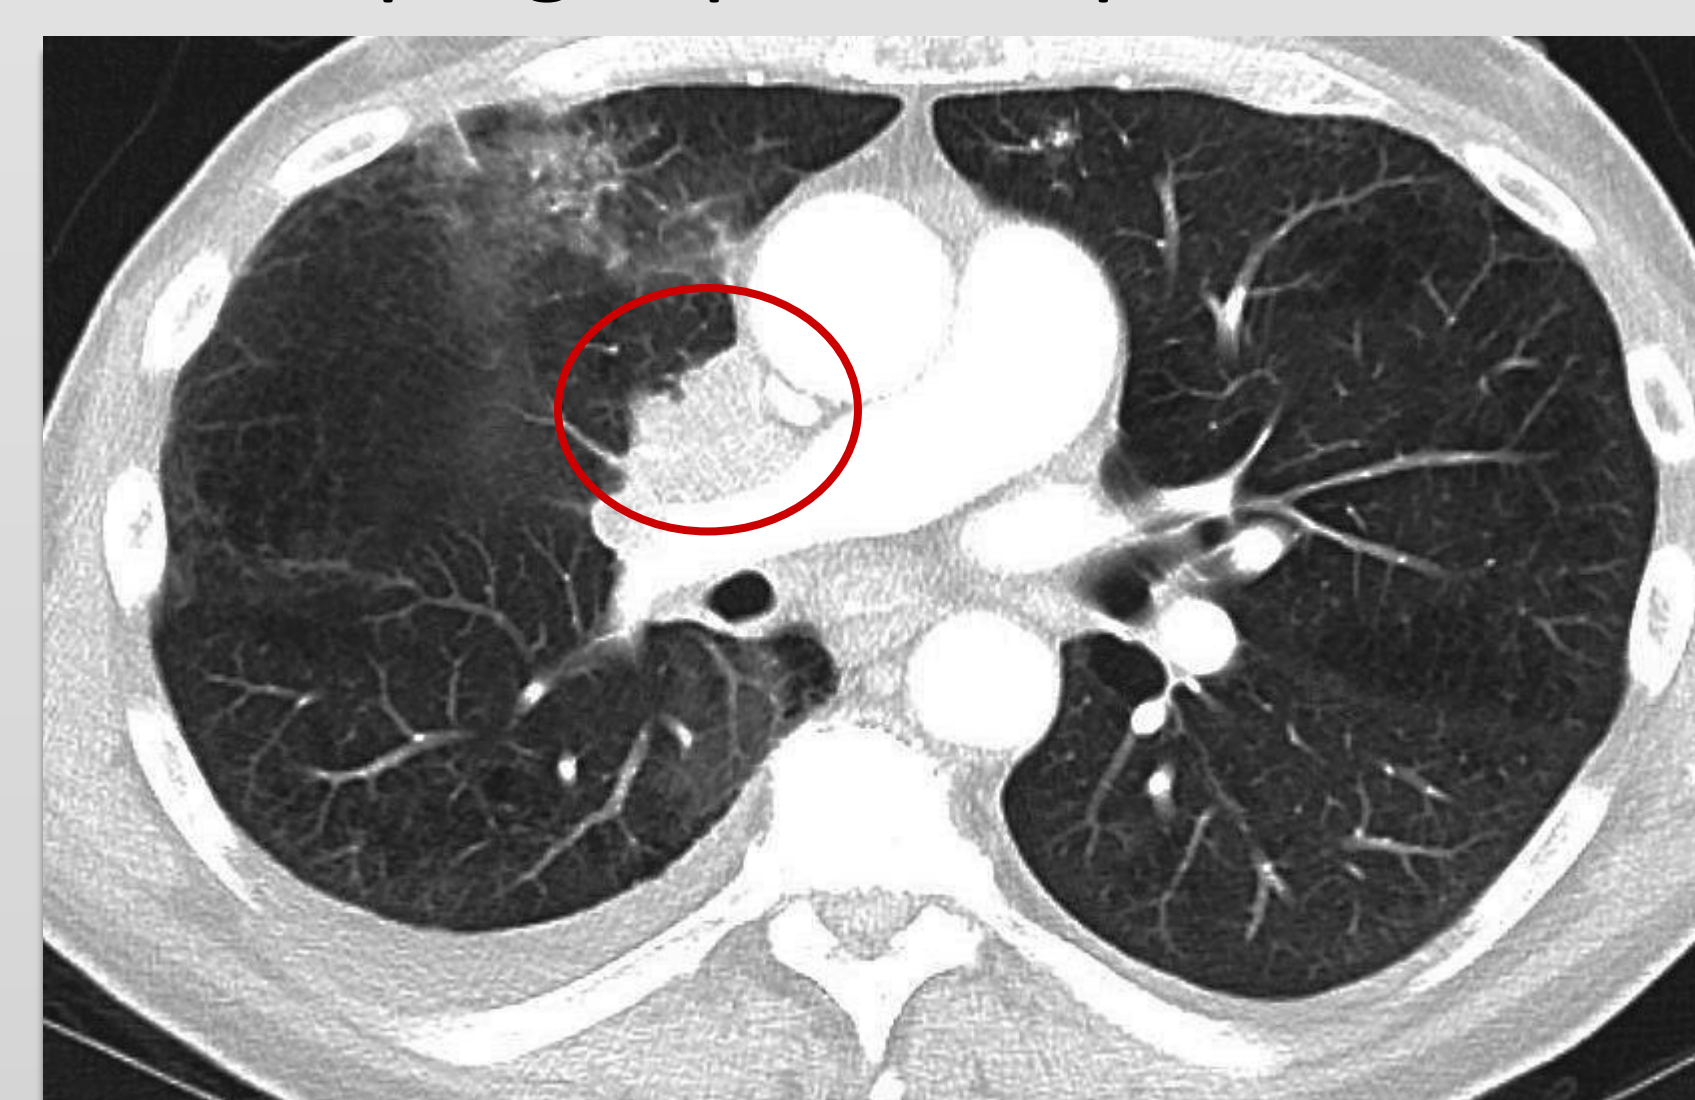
Chest CT demonstrating a 6.9 right perihilar/mediastinal mass (circled) compressing the right pulmonary artery and mainstem bronchi with additional lymphangitic carcinomatosis of the right upper lobe.
